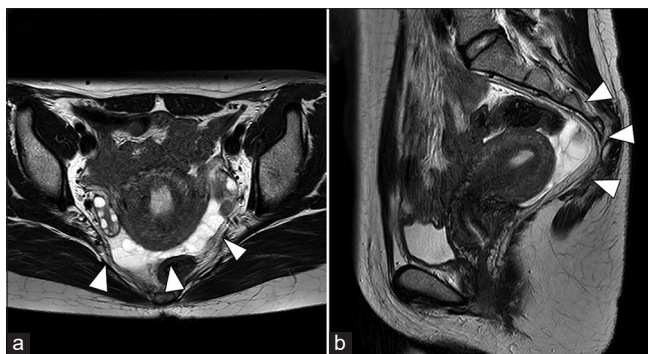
Magnetic resonance images of the pelvic cysts. T2-weighted magnetic resonance images of the sagittal (a) and axial planes. (b) Triangles show multiple cysts of the rectouterine pouch
